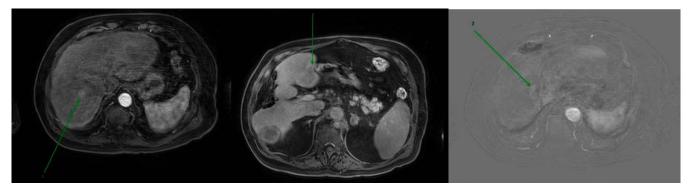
MRI 1 month before ablation. Arrows point to 3 different lesions in the liver, with the middle lesions being adjacent to the stomach. MRI, magnetic resonance imaging.
